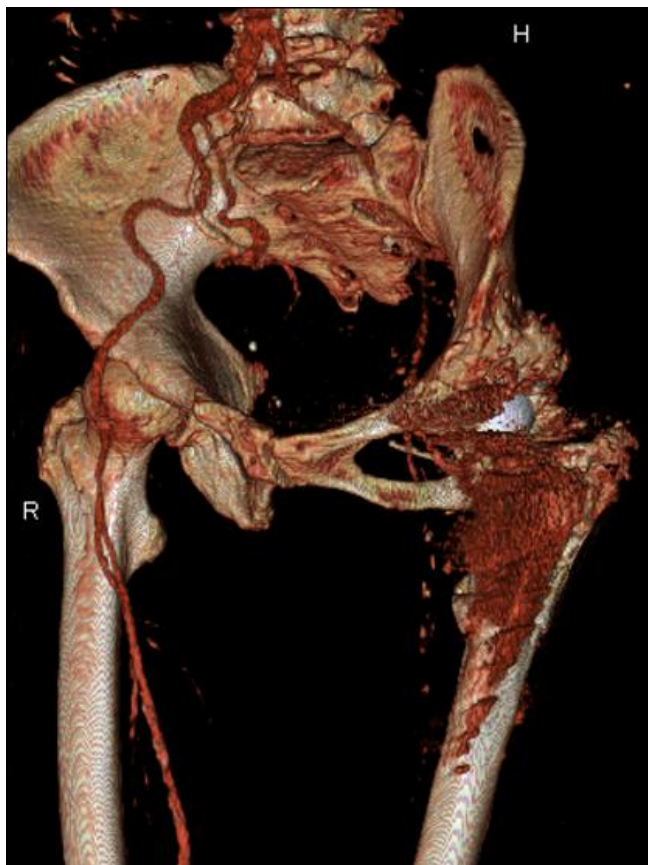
Multiscan CT angiography in the patient with acute iliac and femoral arterial thrombosis secondary to total hip arthroplasty.
